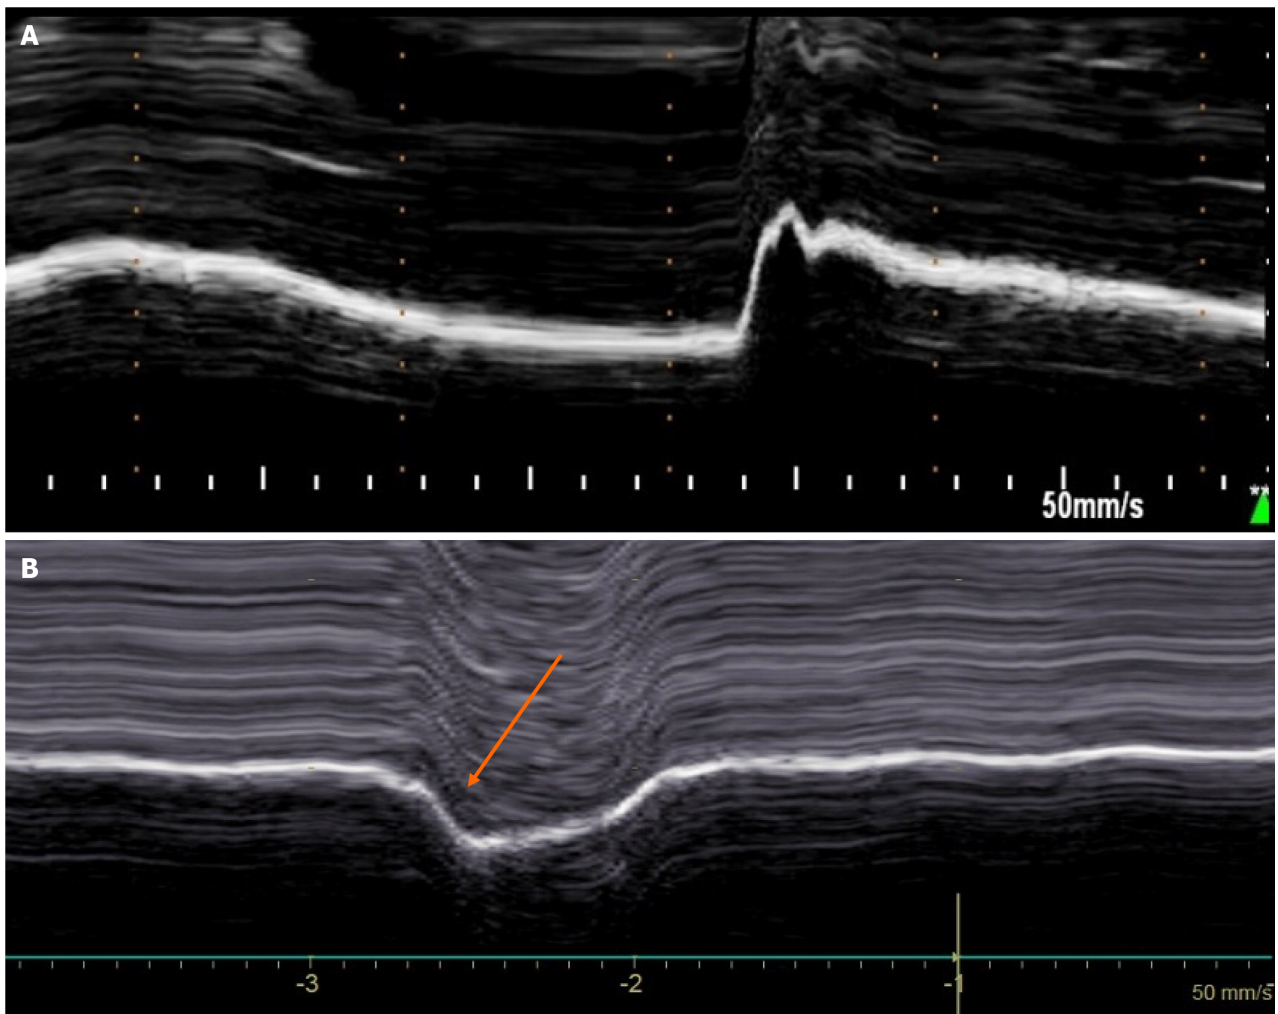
Diaphragmatic motion recorded by M-mode ultrasonography during voluntary sniffing. A: Normal motion; B: Paradoxical movement (arrow) in patient with hemidiaphragm paralysis.
